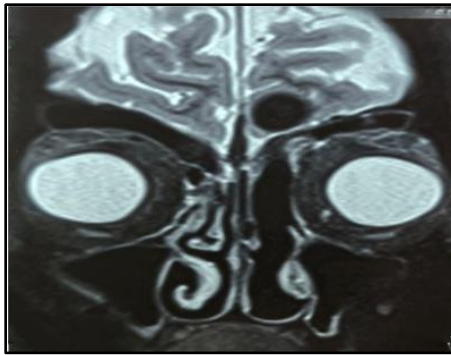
Post- operative MRI of left oncocytic schneiderian papilloma
